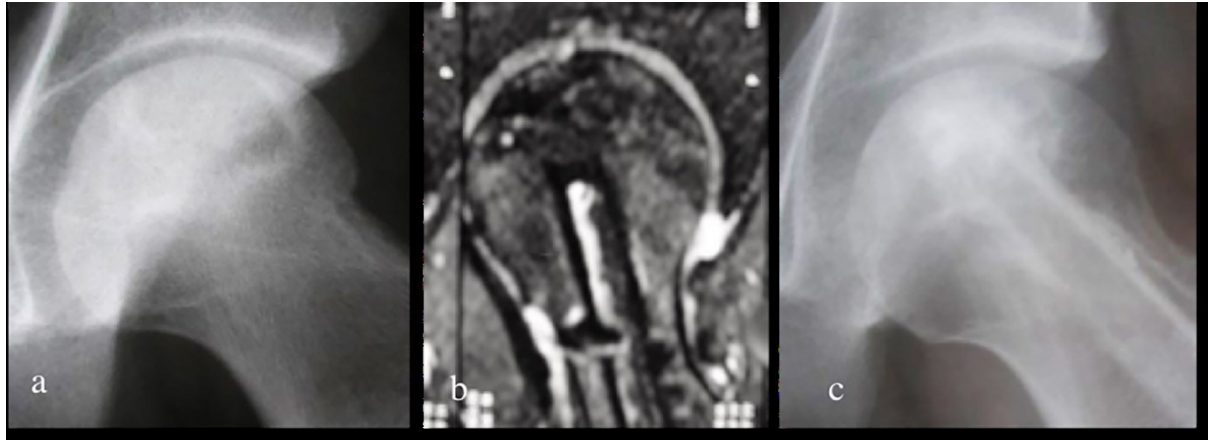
Surgical treatment of FH ON with the implantation of vascularised fibula graft. (a) Preoperative radiograph. (b) and (c) Postoperative MRI and radiograph depicting the implanted fibula.
